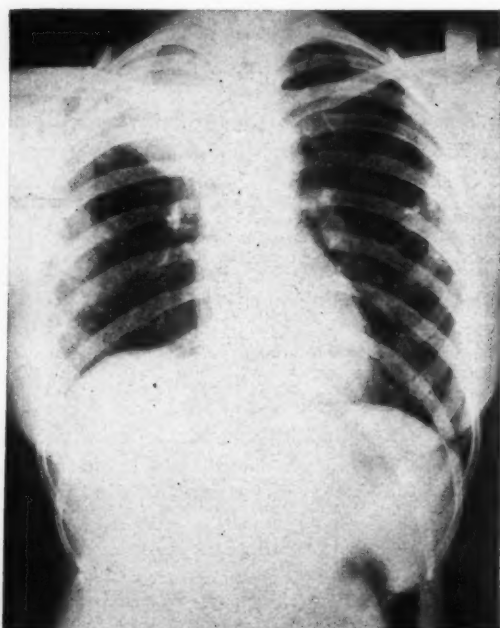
Roentgenogram made on patient's admission showing atelectasis of right upper lobe due to "central" carcinoma.
